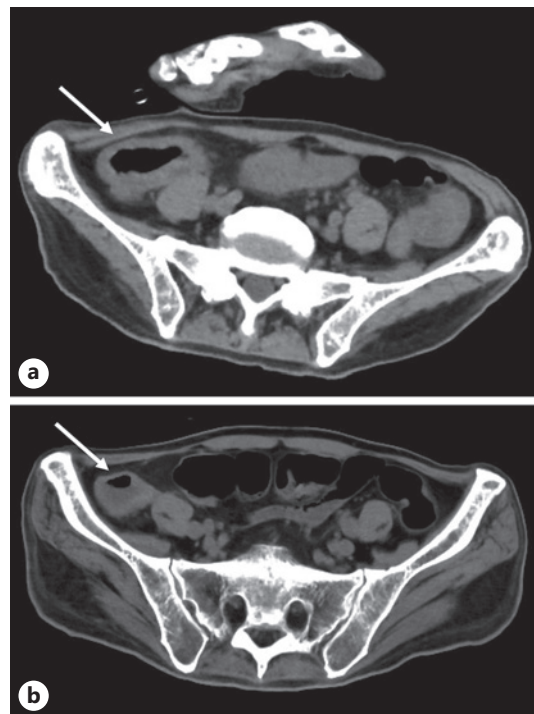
Abdominal computed tomography revealed wall thickness in the cecum (a), which improved 4 months after bowel rest (b).
